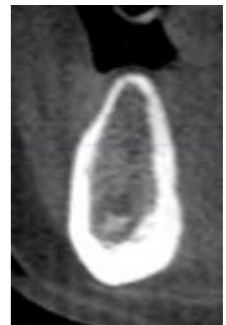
CT scan, site #29, demonstrating buccal deficiency
